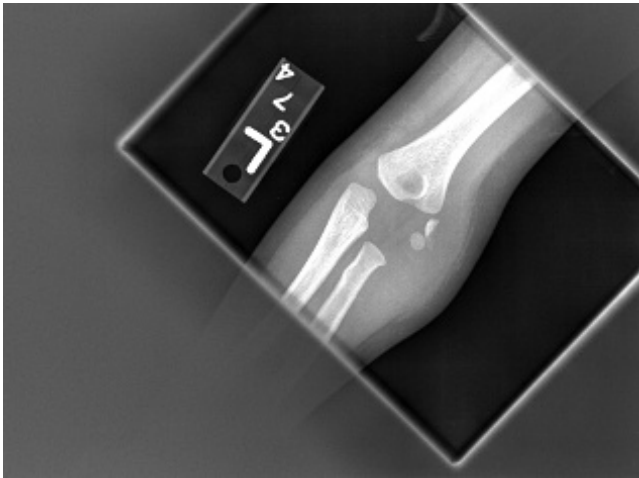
AP x-ray of a 2-year-old male reveals a displaced lateral condyle fracture with the fragment rotated greater than 90°.
